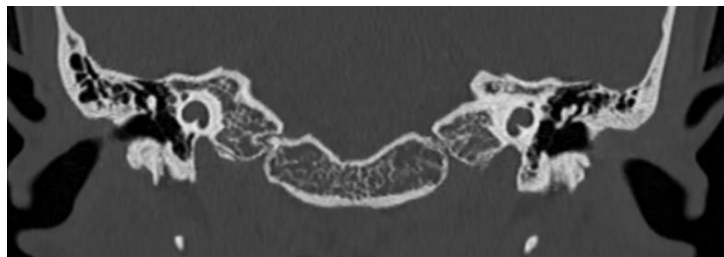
Coronal HRCT image showing a 1.5-turn cochlea with cystic dilatation of the apical turn, consistent with Mondini malformation
